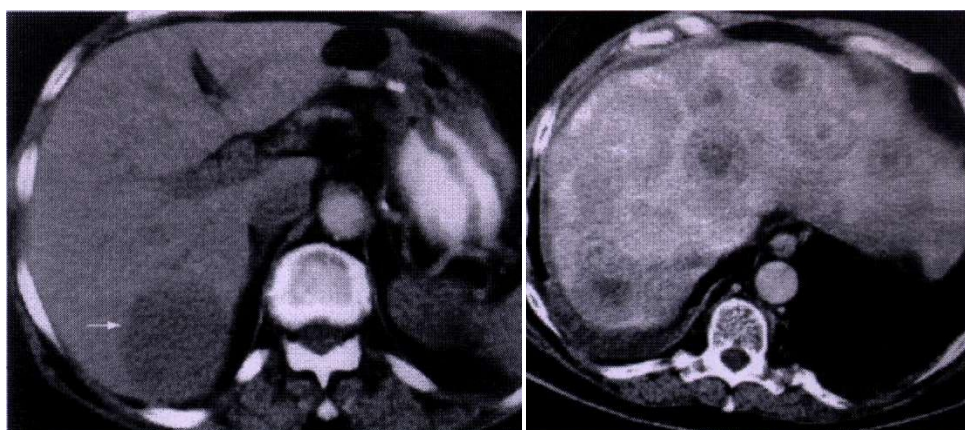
CT scanning with contrast substance of spontaneous liver metastases.
